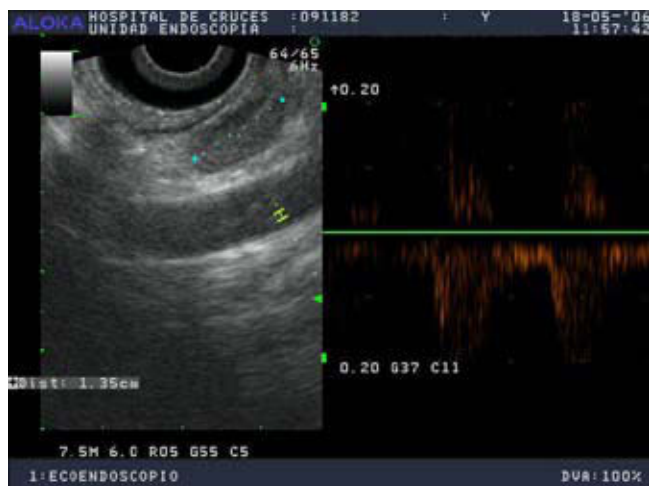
Sectorial endoscopic ultrasound; hypoechoic and well-defined nodule of 1.35 cm, localized between the oesophagus and carotid. A well-defined hypoechoic halo is observed.
